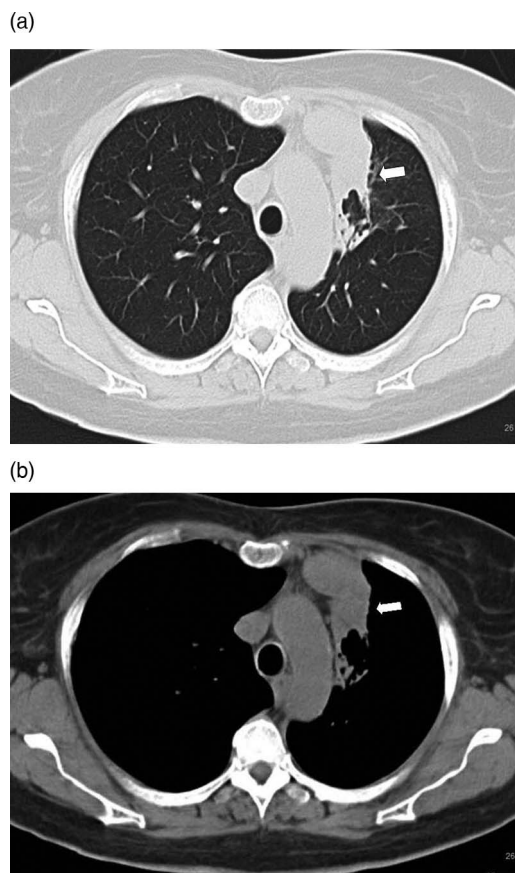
Thoracic CT scan showing mediastinal shift to the left and collapse of left upper lobe (white arrow) (A) lung window and (B) mediastinal window.
